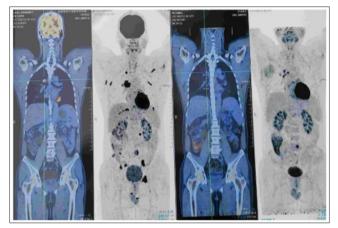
Comparison between the third (left-hand side two panels) to the second (right-hand side two panels) PET-CT images, showing rebound of previously regressing tumors and appearance of new metastasis.
